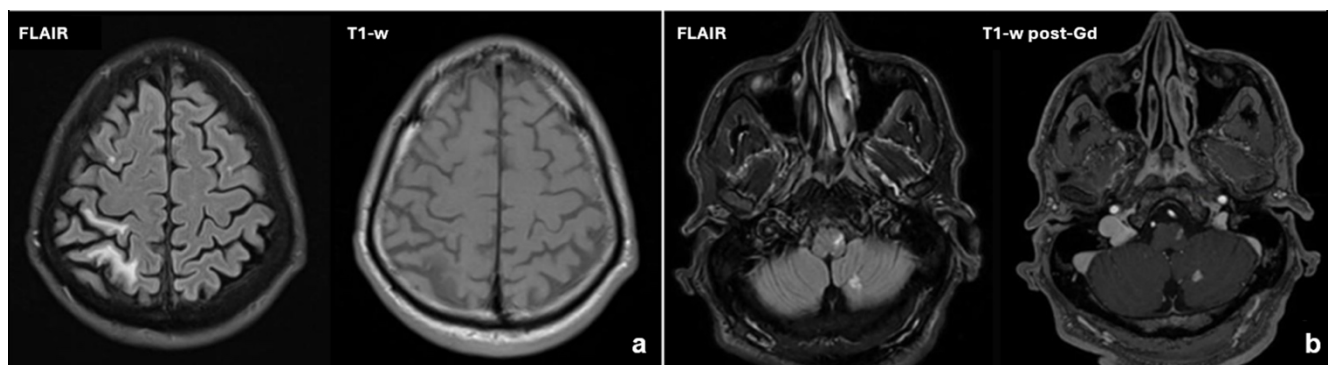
Imaging data of case 3 (subacute ischemic stroke). Subcortical right parietal lesion was hyperintense on FLAIR and hypointense on T1-w (a). Follow-up imaging at 4 months (b) revealed a FLAIR hyperintense sequela with nodular enhancement on T1-w post-Gd images, with a highly typical pattern for a medullary infarct (anterolateral pattern with associated cerebellar involvement). *Abbreviations:* FLAIR, fluid attenuated inversion recovery; T1-w, T1-weighted images; T1-w post-Gd, T1-weighted post-gadolinium injection.
